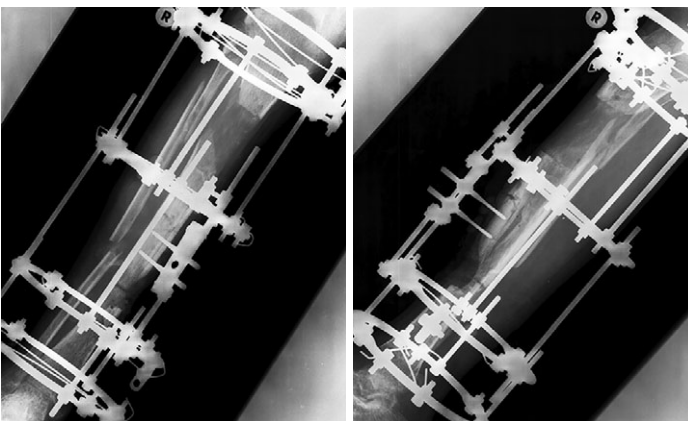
X-rays of the lower leg in frontal and lateral projections after the formation of the marginal "split" of the tibia
